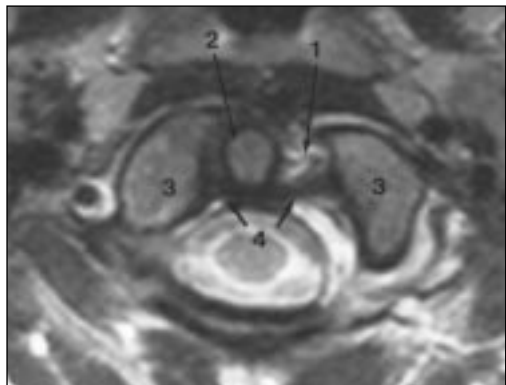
Left alar ligament tear in 19-year-old woman with severe neck pain after fall on her head while snowboarding. Fixed deviation of dens to right was seen on radiograph (not shown). C1–2 rotatory subluxation was suspected. Axial T2-weighted MR image (TR/TE, 4000/90) obtained on 1.0-T MR scanner shows isolated tear of left alar ligament (1) and deviation of dens (2) toward right with respect to lateral masses of C2 (3). Transverse ligament (4) is intact. Sagittal images (not shown) depict normal alignment of occipital condyles with C2, thus no rotatory subluxation is present. CT performed before MR imaging was negative for fracture and fixed rotatory subluxation. These results allowed confident symptomatic treatment that led to full recovery.
